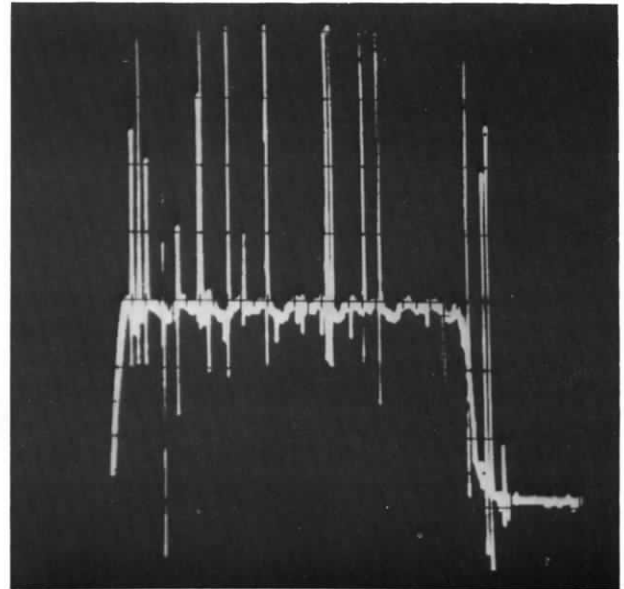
Excessive spikes on x-ray output waveform.
